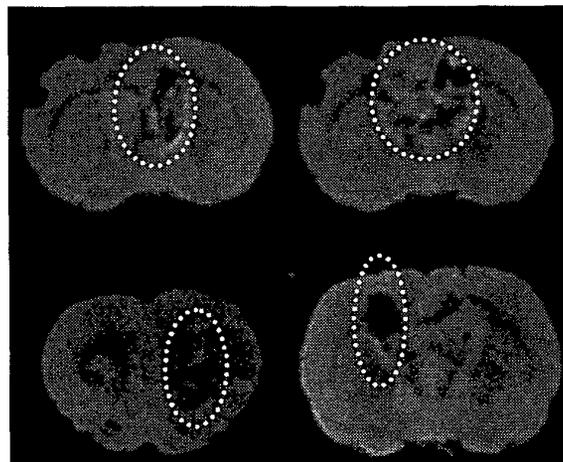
Deformation in the central region (top row) and lateral regions (bottom row) in the brain revealed by MRI imaging (anterior coronal view).
